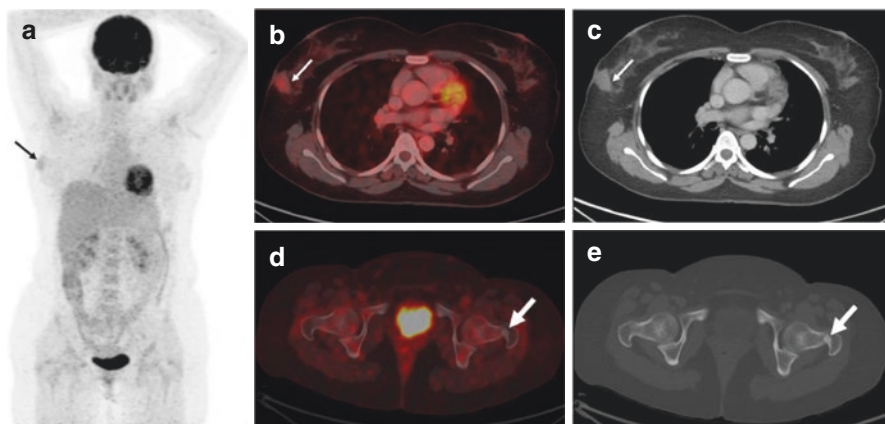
A 38 year-old-woman with right breast carcinoma (IDC, grade II) – initial staging done with ^{18}F -FDG PET/CT – AJCC Stage IV (shown in Fig. 12.2). ^{18}F -FDG PET/CT was performed for response assessment, after the patient had received 8 cycles of chemotherapy. Maximum intensity projection image (a) shows absent brown fat uptake of ^{18}F -FDG (compare with Fig. 12.2). Trans-axial fused PET/CT (b) and CT (c) images show a mildly tracer avid right breast lesion (thin-arrow), with significant reduction in size and ^{18}F -FDG uptake; and a non-tracer avid sclerotic lesion in the neck of the left femur (d, e; thick-arrow). The appearance of sclerosis and resolution of ^{18}F -FDG avidity denotes healing of the osseous metastasis. Overall findings suggested favourable response to therapy
